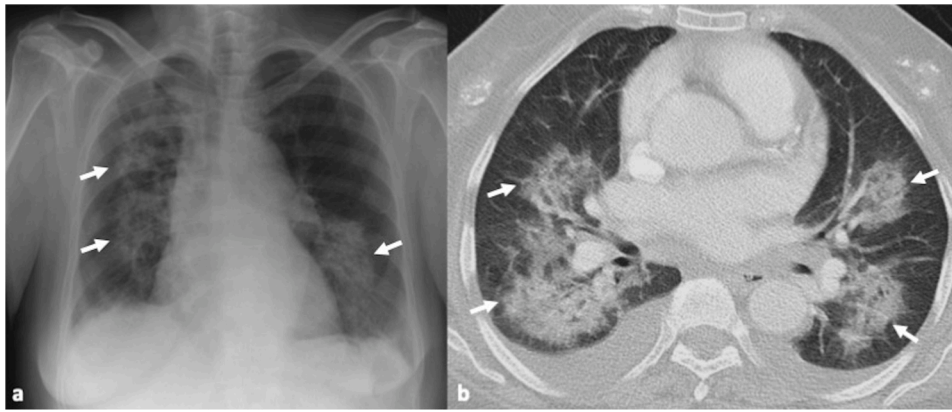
67-year-old female patient with pneumonia due to cytomegalovirus following kidney transplantation. 14a. Chest x-ray shows bilateral air-space opacification (arrows). 14b. Axial CT image shows the bilateral patchy areas of consolidation and ground glass opacity (arrows) associated with bilateral pleural effusions.
